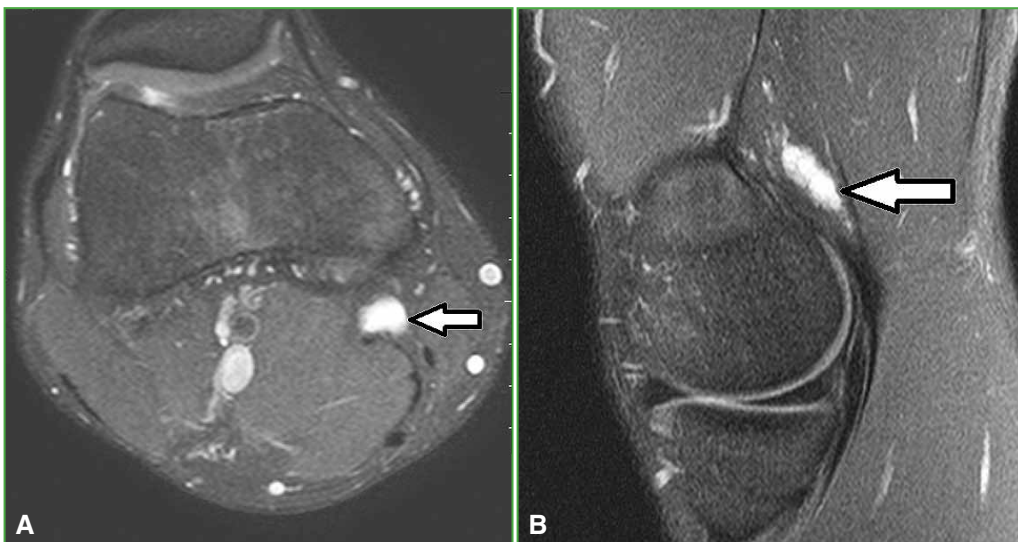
Knee MRI, axial (A) and sagittal (B) STIR sequences. Focal injury in the distal insertion of the semimembranosus muscle, resulting from effort during competition (arrows).
